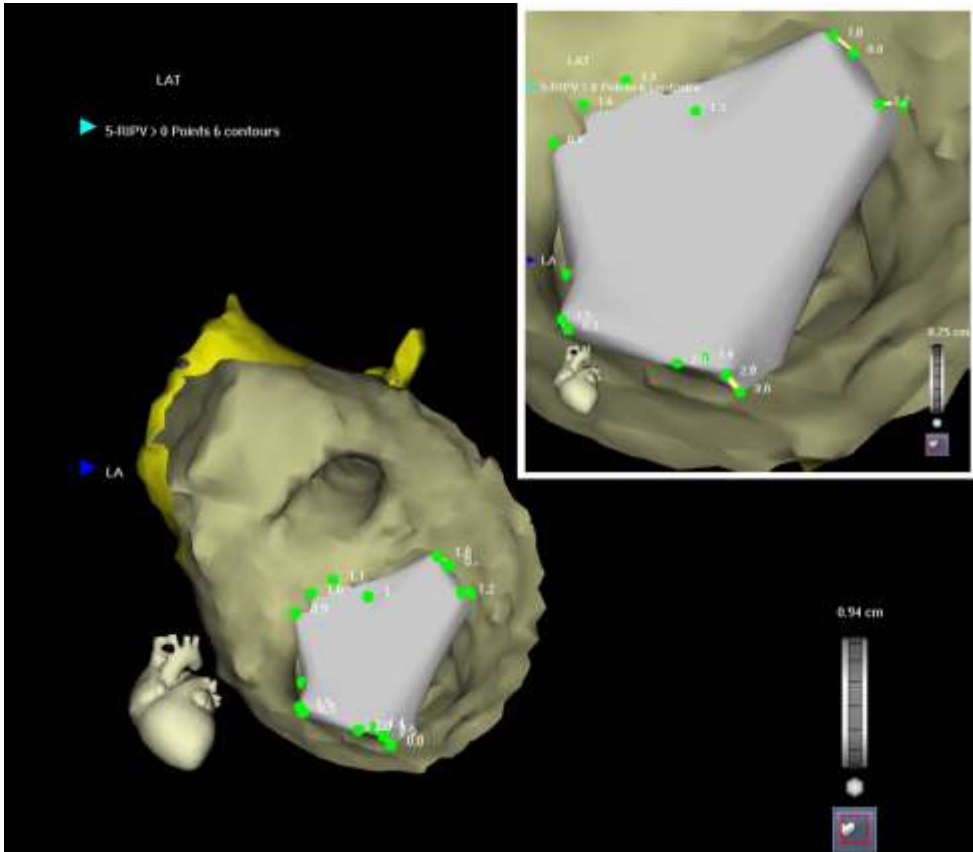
The quality of the registration process was reviewed at the level of the pulmonary vein ostium by measuring the distance between multi-slice computed tomography and three-dimensional map at 5 representative points.
